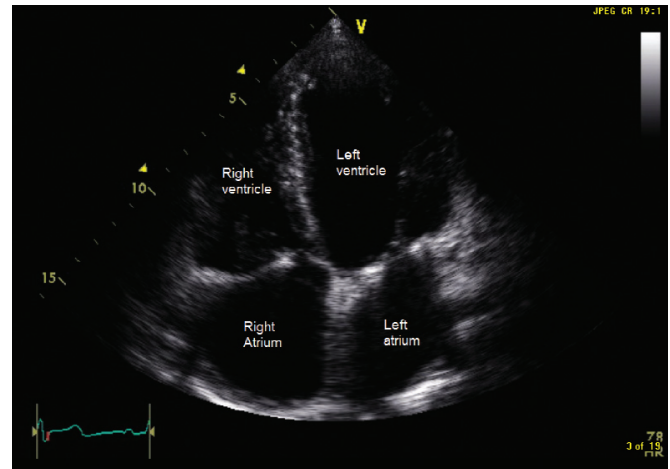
Transthoracic echocardiographic apical 4-chamber view taken 4 months postoperatively showing a marked reduction in the size of all 4 chambers. The ventricular end-diastolic dimensions in particular have been reduced from 6.8 cm to 4.9 cm. There was no significant mitral or tricuspid regurgitation.
